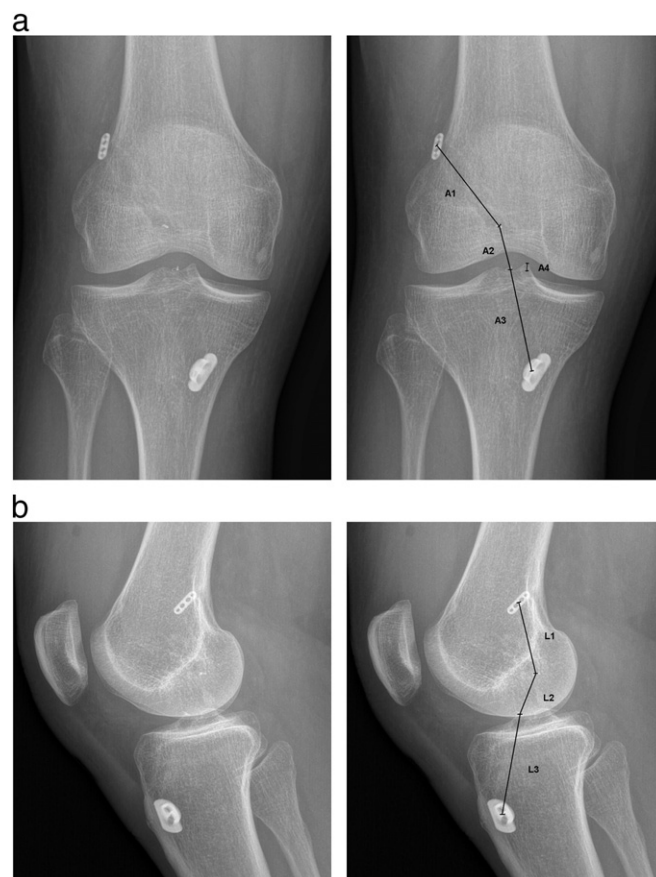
a: Anteroposterior (ap) X-ray with four ap marker distances: A1: proximal fixation–proximal marker; A2: proximal marker–distal marker; A3: distal marker–distal fixation; A4: intercondylar eminence–distal marker. The center of the proximal fixation (FlIPTack, Karl Storz, Tuttlingen, Germany) and distal fixation (Endotack, Karl Storz, Tuttlingen, Germany) device was used for measurements. b: Lateral X-ray with three lateral marker distances: L1: proximal fixation–proximal marker; L2: proximal marker–distal marker; and L3: distal marker–distal fixation.
